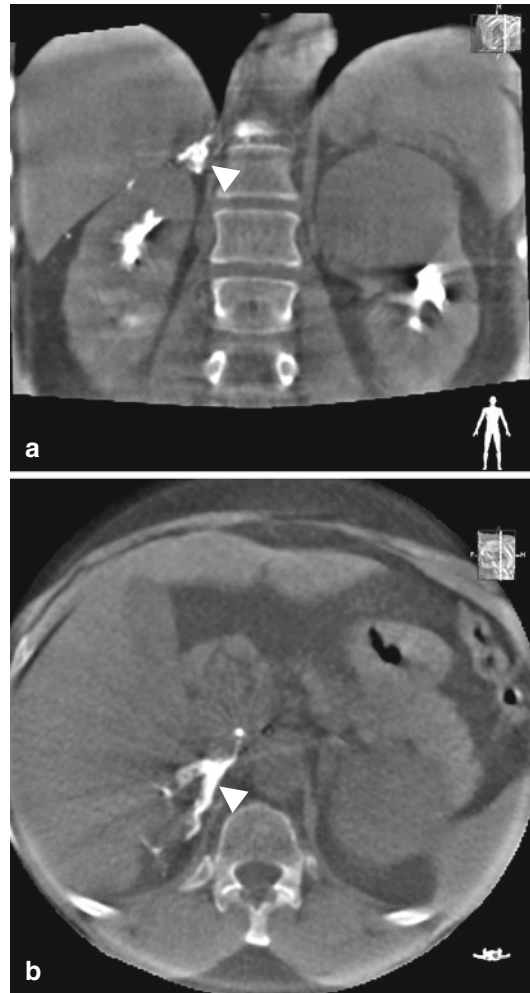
(a, b) C-arm CT of the adrenal gland. (a, b) Coronal and axial MPR of C-arm CT performed during hand injection of contrast medium via a catheter in the adrenal vein demonstrate opacification of the right adrenal gland (white arrowhead), confirming proper catheter position. The medial and lateral limbs of the gland are clearly identified. (Images courtesy of Christos Georgiadis, Johns Hopkins School of Medicine, The Russell H. Morgan Department of Radiology and Radiological Science)
